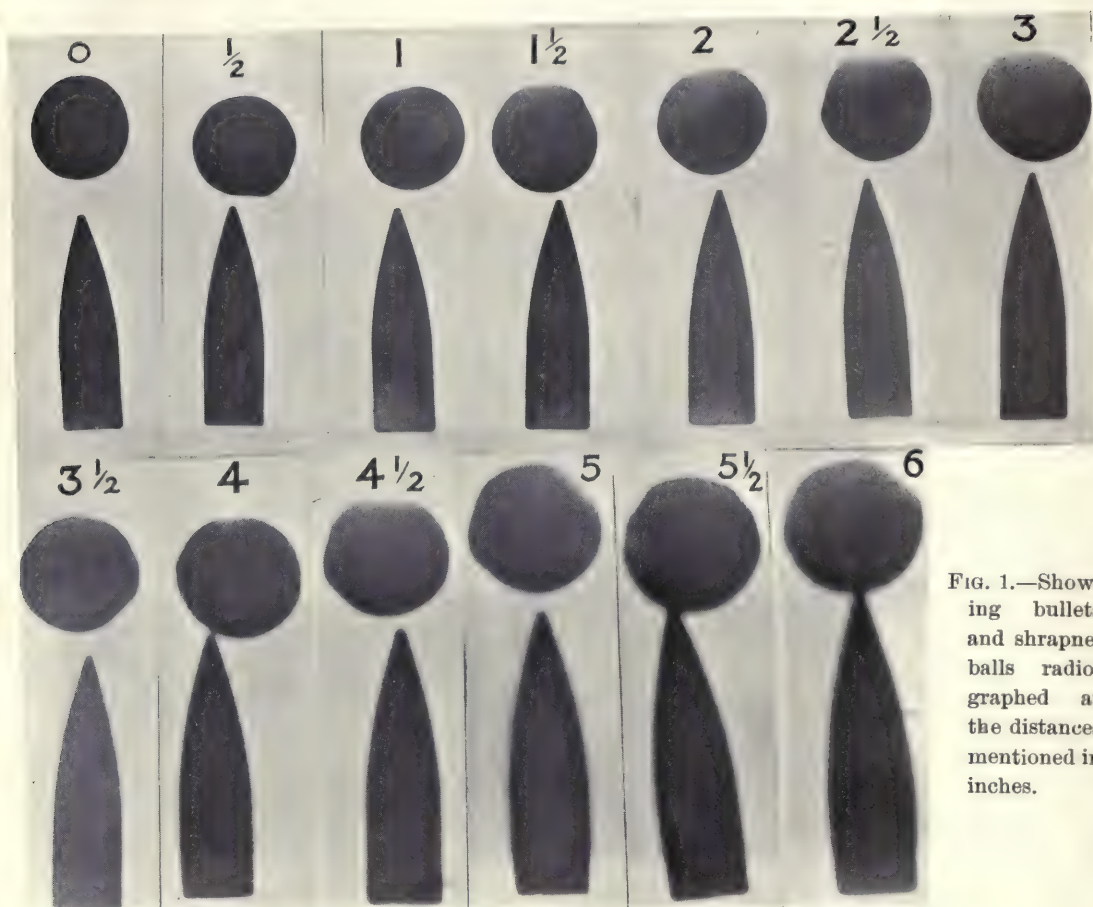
Showing bullets and shrapnel balls radiographed at the distances mentioned in inches.
